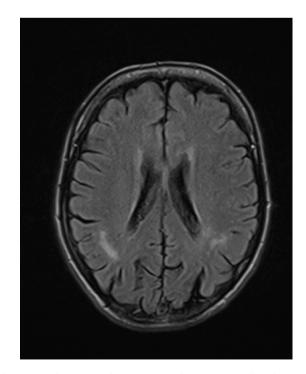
Brain magnetic resonance image scan showing ischaemic lesions in the parietal regions.
